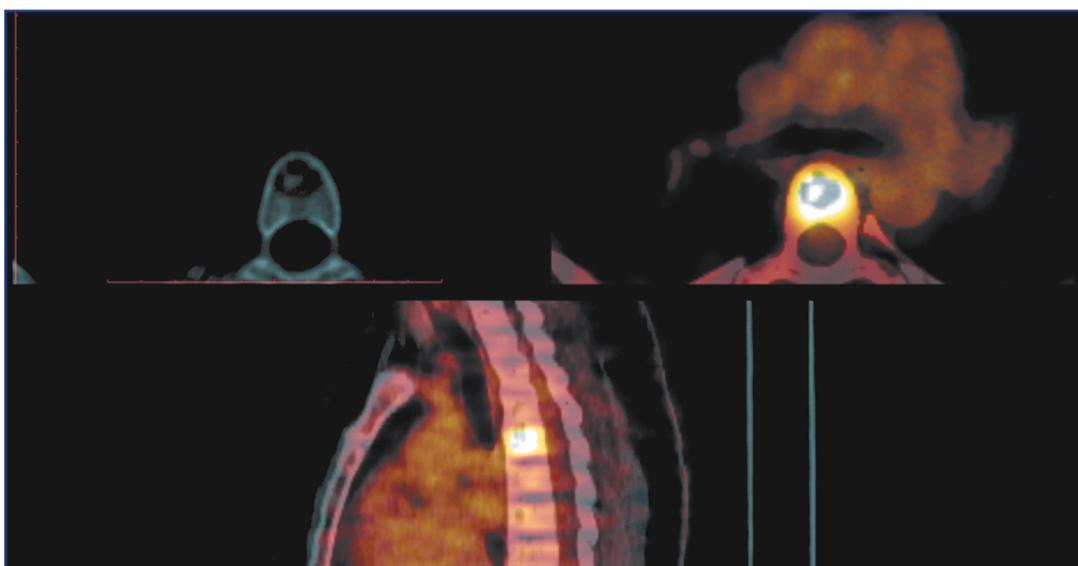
PET/CT. Metastasis to the body of the Th5 vertebra.
